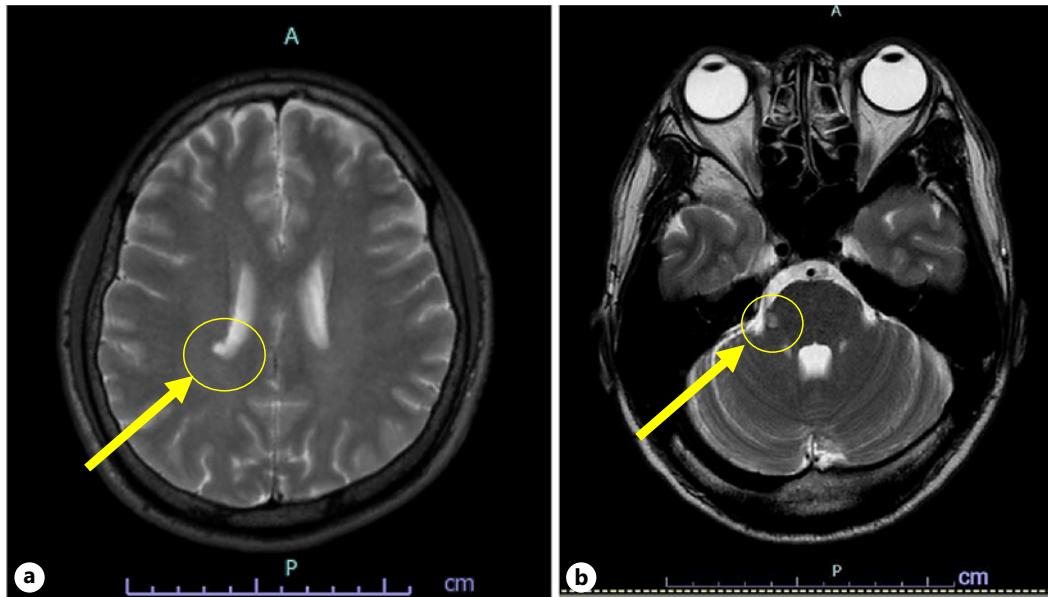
T2-weighted MRI only shows pretreated metastasis lesion without any signs of leptomeningeal enhancement or enlargement of the ventricles. a 6 mm metastasis by the central part of lateral ventricle. b 5 mm nodule on the right basis pontis.
